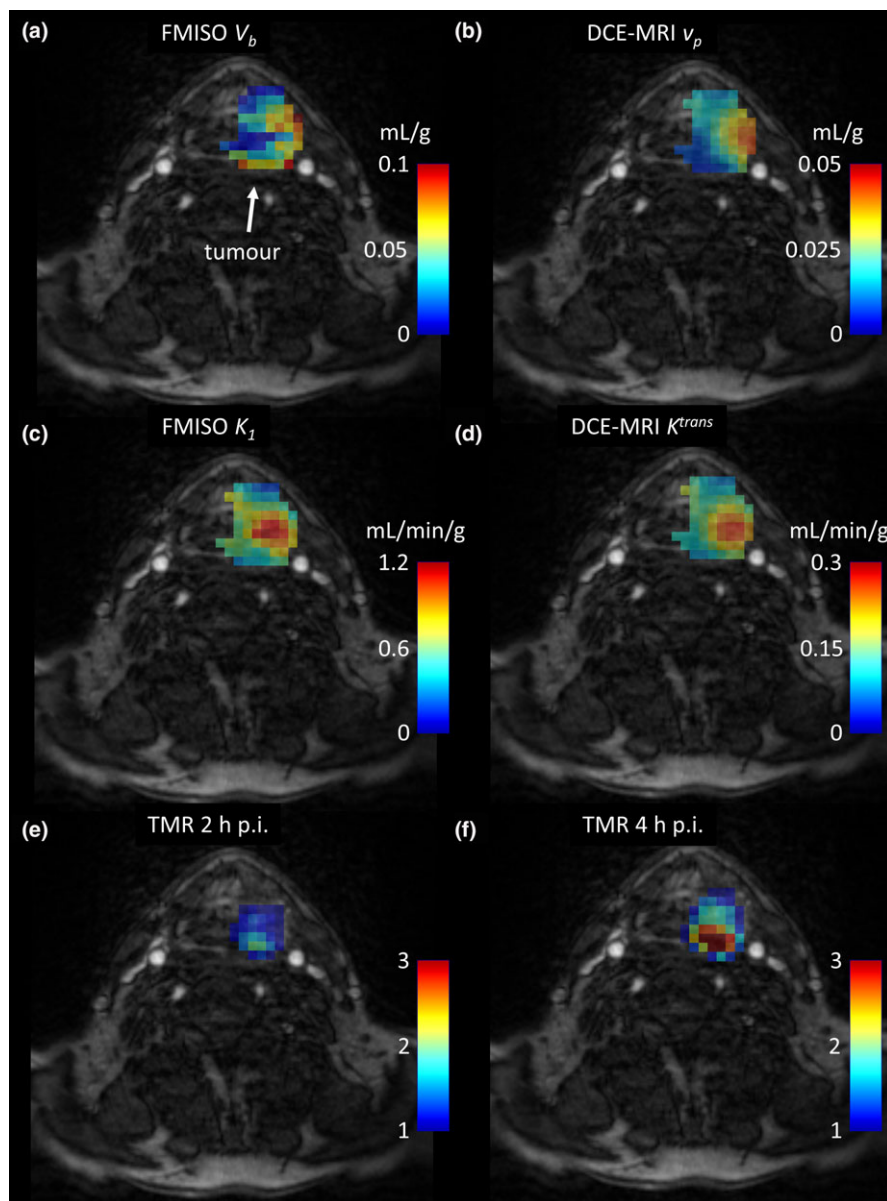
Contrast-enhanced MRI images of the patient P4, overlaid with the FMISO V_b and DCE-MRI v_p parametric images (a) and (b), FMISO K_1 and DCE-MRI K^{trans} parametric images (c) and (d), and TMR maps at 2 h and 4 h post injection (e) and (f). [Color figure can be viewed at wileyonlinelibrary.com]
